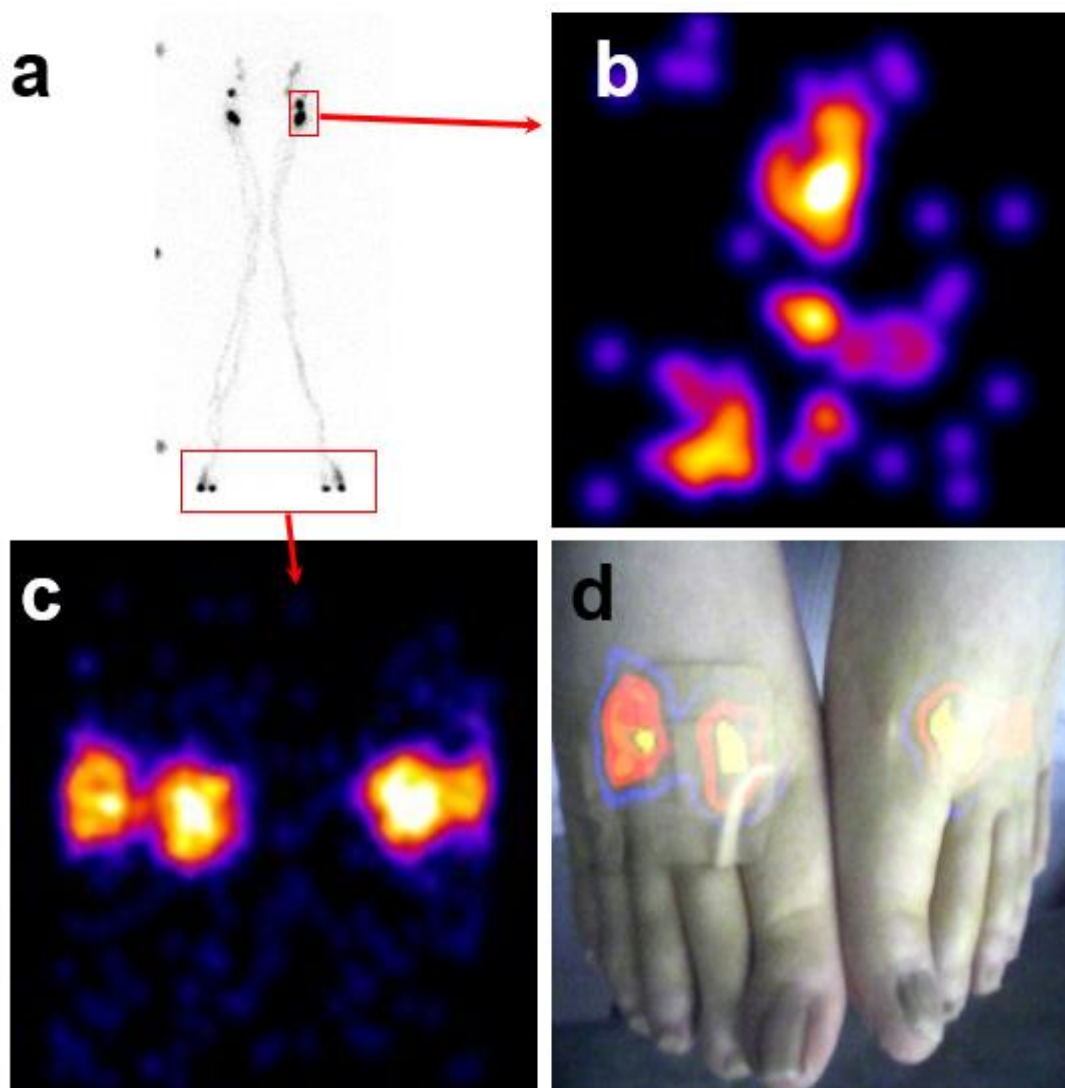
Example of the gamma and hybrid images acquired by HGC (1 mm pinhole collimator) in patient administered with 12 MBq of  $^{99m}\text{Tc}$ -nanocolloid at each injection site (two injections on each foot) undergoing lymphoscintigraphic imaging. Image (a) is an anterior planar image of lower extremities, produced by a standard LFOV gamma camera, 20 minutes following administration with a 17 minutes acquisition time showing focal uptake at the injection site and the inguinal region bilaterally with high activity on the left and right site. Image (b) is the gamma image acquired by HGC on the left inguinal region with 5 minutes acquisition time. Gamma image of the feet (c) was acquired by HGC positioned at a distance of 21 cm with 5 minutes imaging time, subsequently superimposed with the optical image (d).
